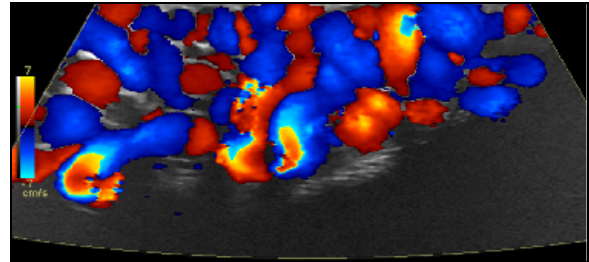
Doppler ultrasound shows dilated serpiginous veins within the left testicle, consistent with a moderate-large varicocele.
